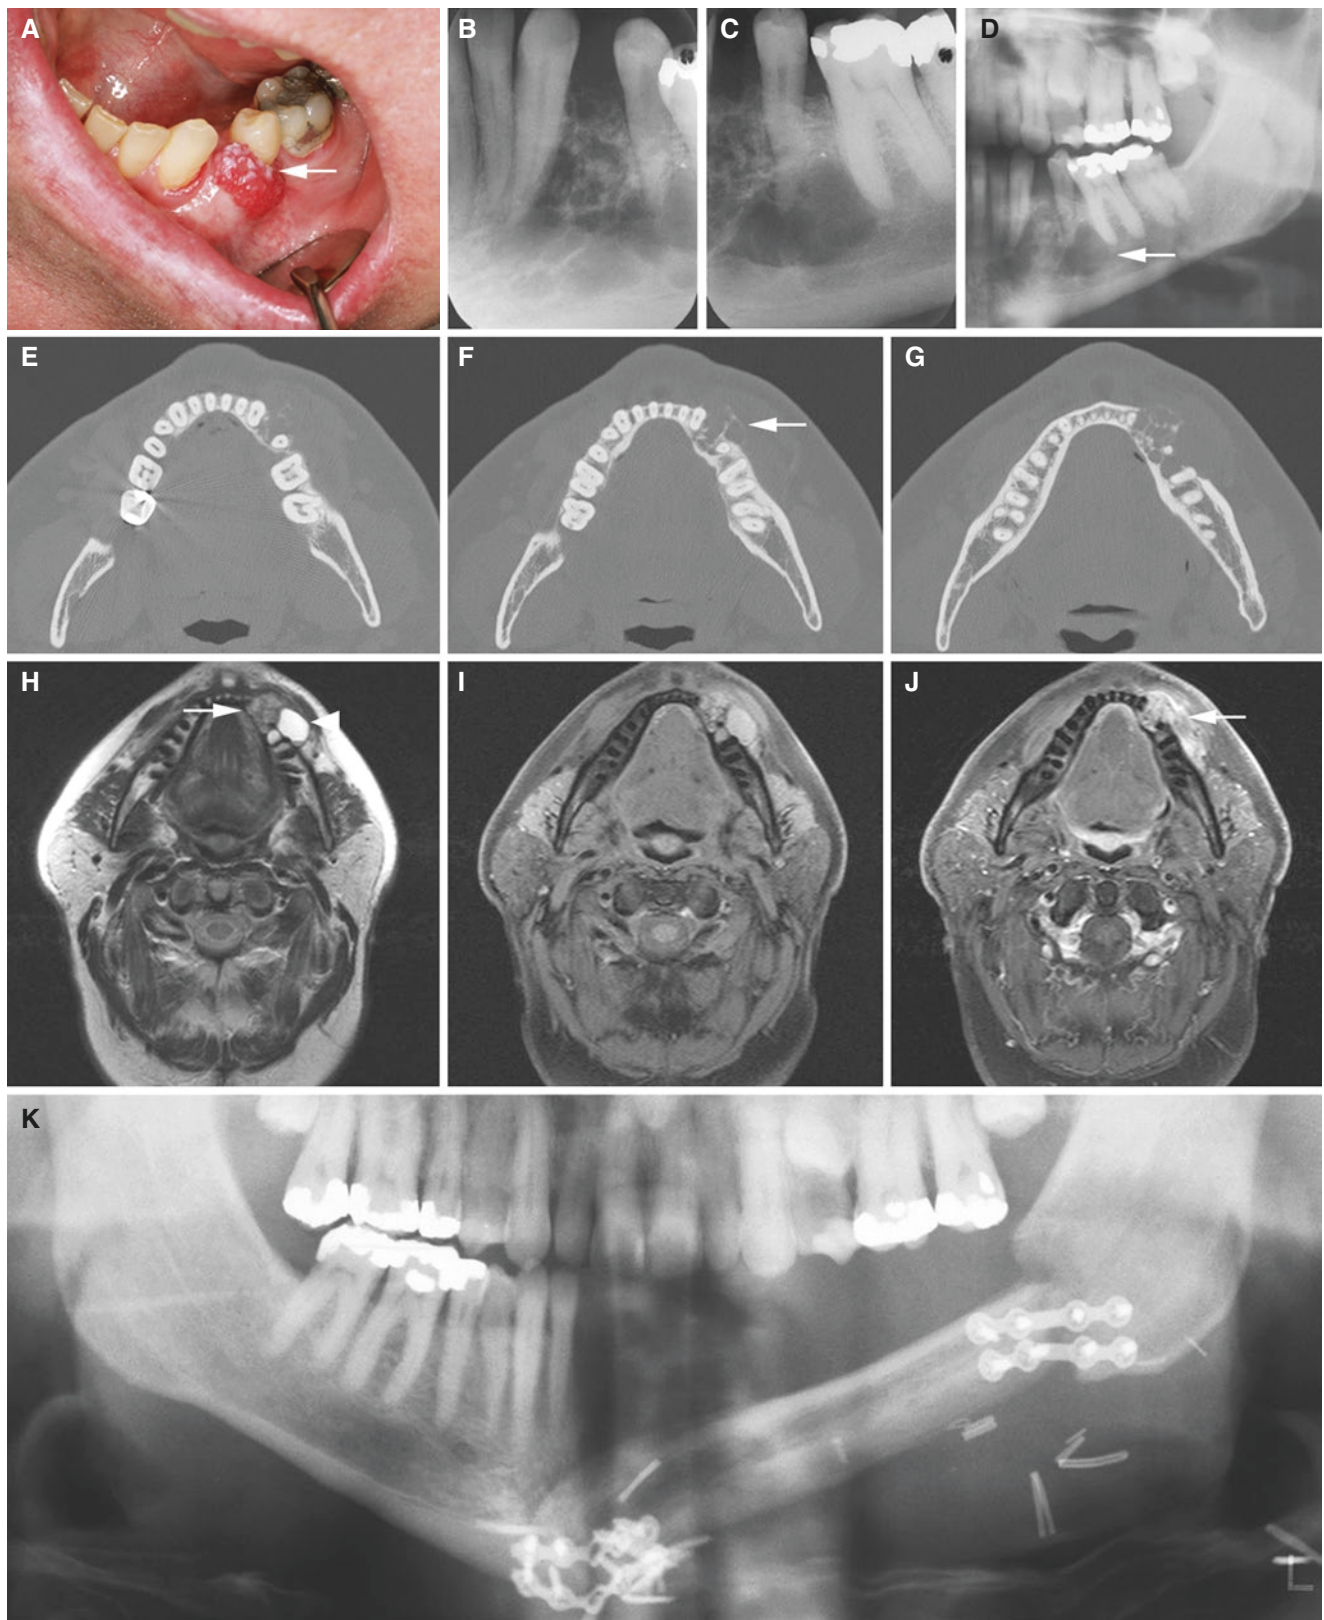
Ameloblastoma, solid/multicystic, mandible; 59-year-old male with gingival mass but no pain or discomfort. (A) Clinical photograph shows exophytic gingival mass with granular red and white appearance (arrow). (B, C) Intraoral and (D) panoramic views show multilocular radiolucency (arrow). (E, F, G) Axial CT images show radiolucency with destroyed buccal cortex (arrow). (H) Axial
